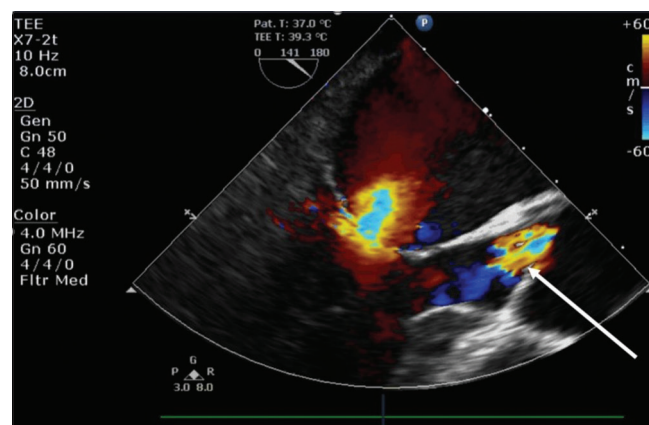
Mid-esophageal long-axis transesophageal echocardiography still image demonstrating a moderate degree of aortic insufficiency (arrow)
